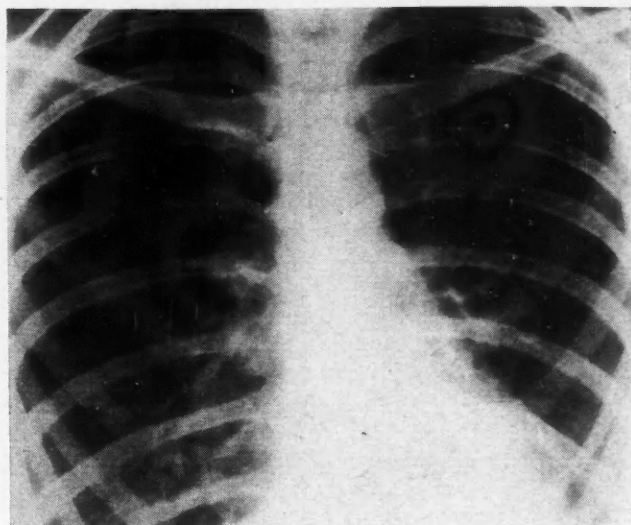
Chest roentgenogram taken April 29, 1954.
